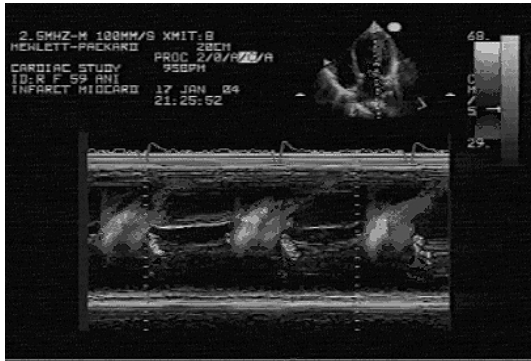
M-mode Doppler Color echocardiography
